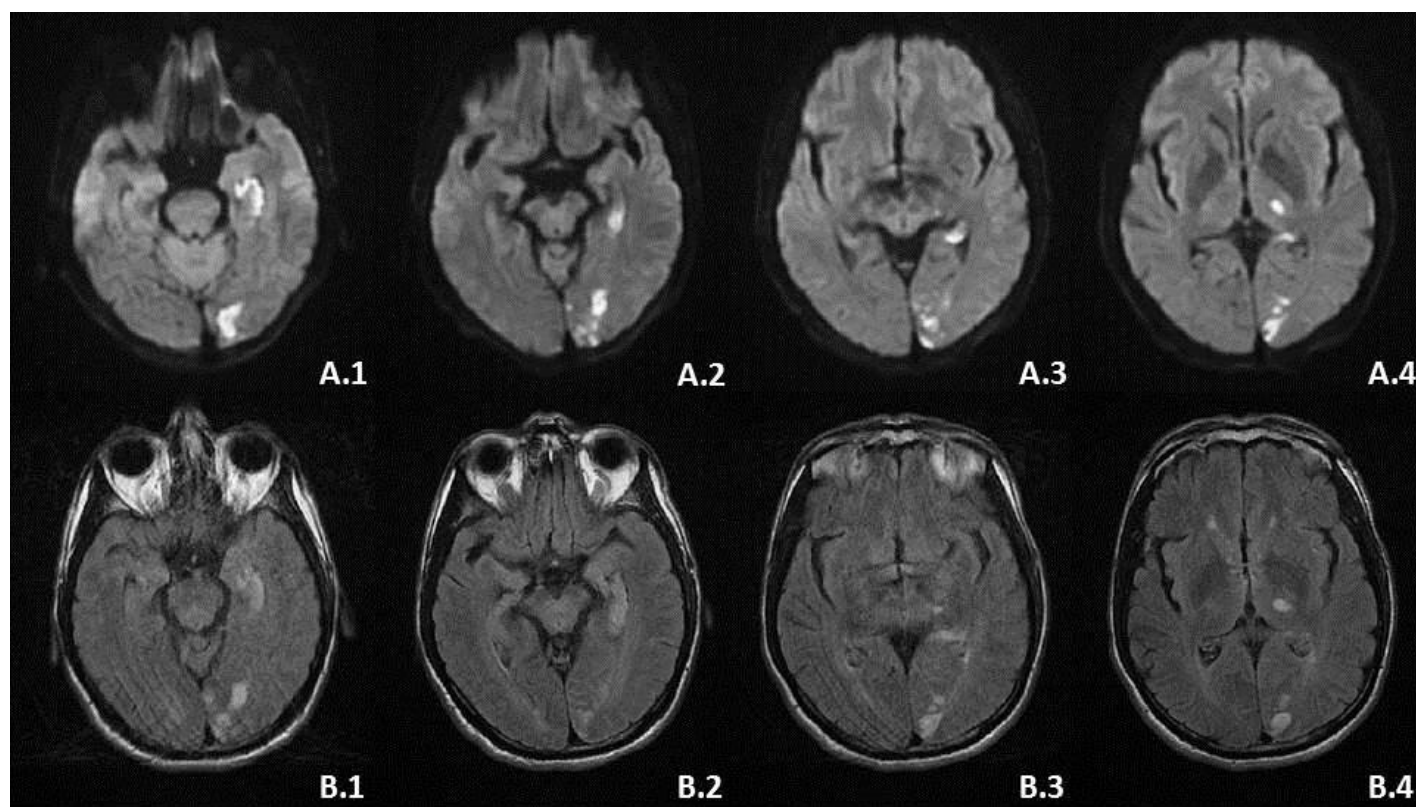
Diffusion (A.1 to A.4) and Flair (B.1 to B.4) axial brain MRI cuts, showing the subacute ischemic lesions in the left occipital lobe, hippocampus and thalamus.
